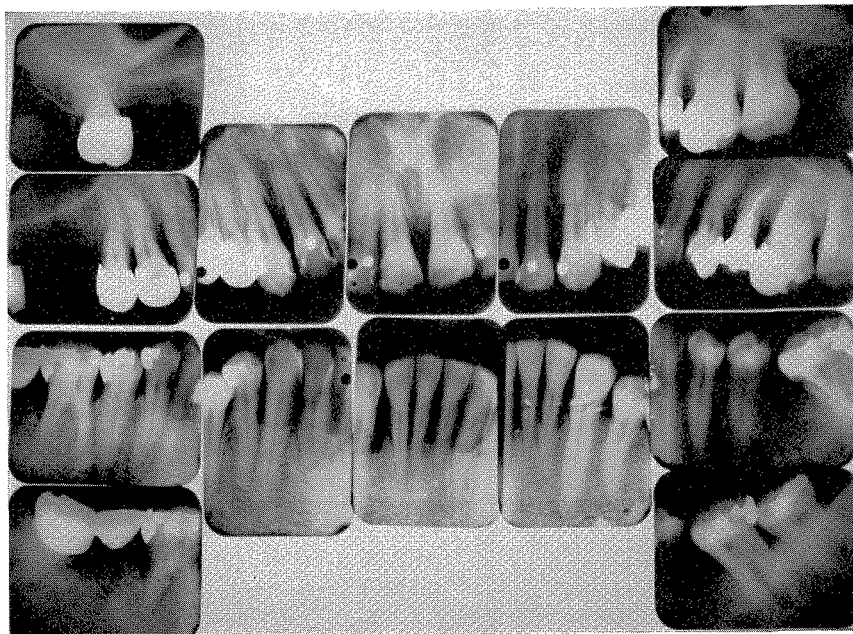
Roentgenograms taken in 1938. Observe extent of periodontal pathology since the 1929 series shown in Fig. 82.
